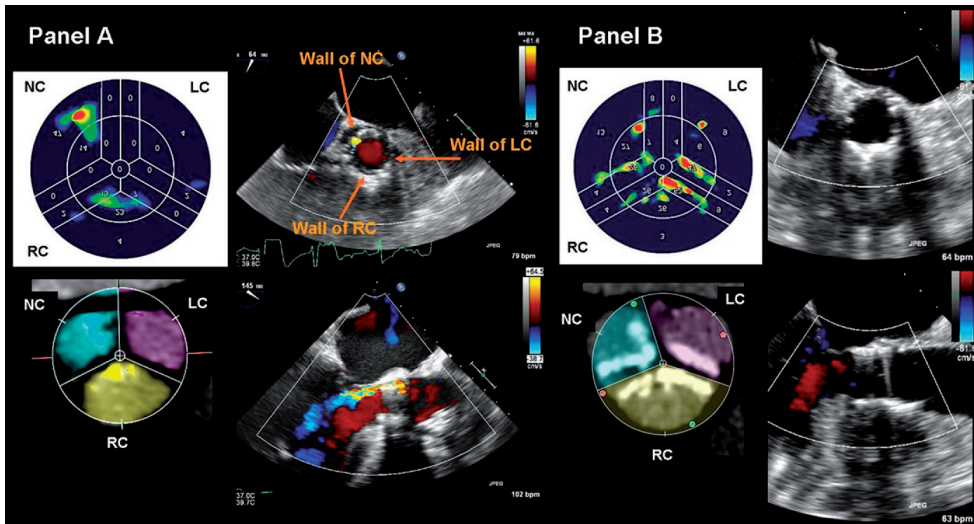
(A) Example showing location and volume of AVC on contrast-enhanced multidetector row computed tomographic scan, as provided by automated postprocessing software and subsequent development of paravalvular regurgitation after TAVI. (B) Example of patient without paravalvular regurgitation after TAVI showing location and volume of AVC on contrast-enhanced multidetector row computed tomographic scan at baseline. Images of MDCT are rotated for easy comparison with corresponding views on transesophageal echocardiogram. Abbreviations as in Figure 2.
